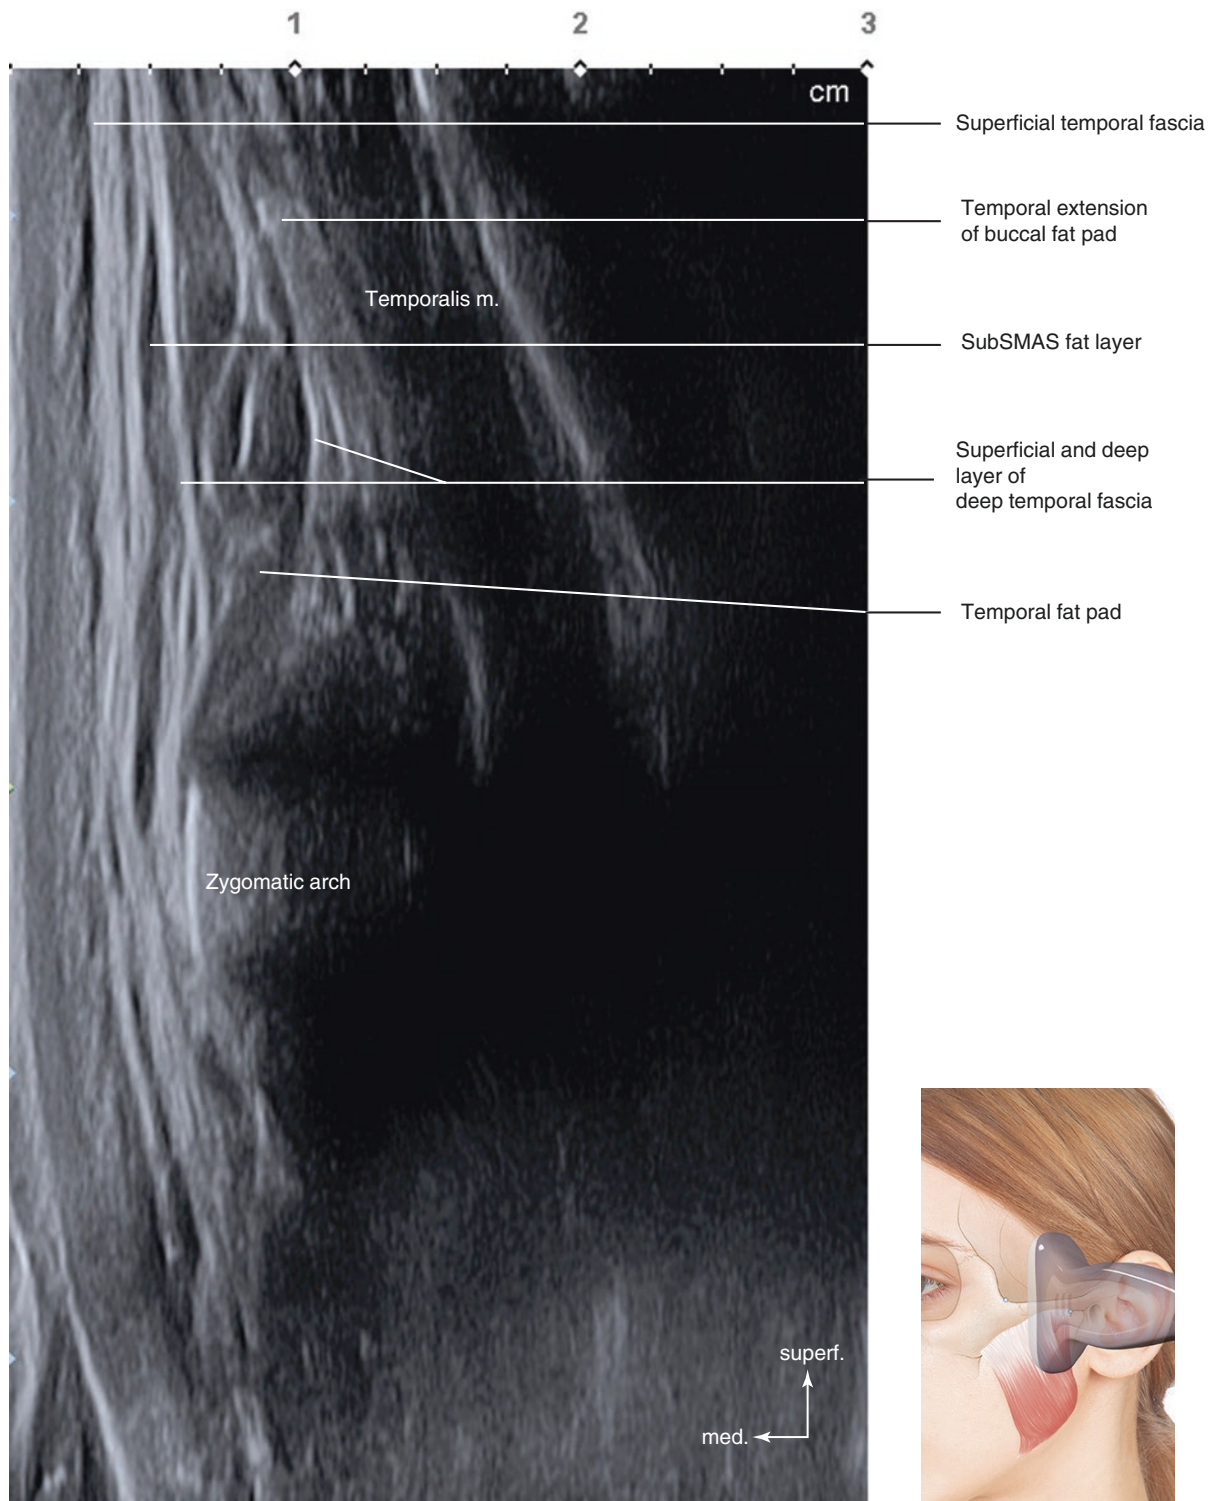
Ultrasonography of the perpendicular line passing the midpoint between T3 and T5 (T4). B mode (coronal view, 15 MHz by linear transducer). (Published with kind permission of © Hee-Jin Kim 2020. All Rights Reserved)
